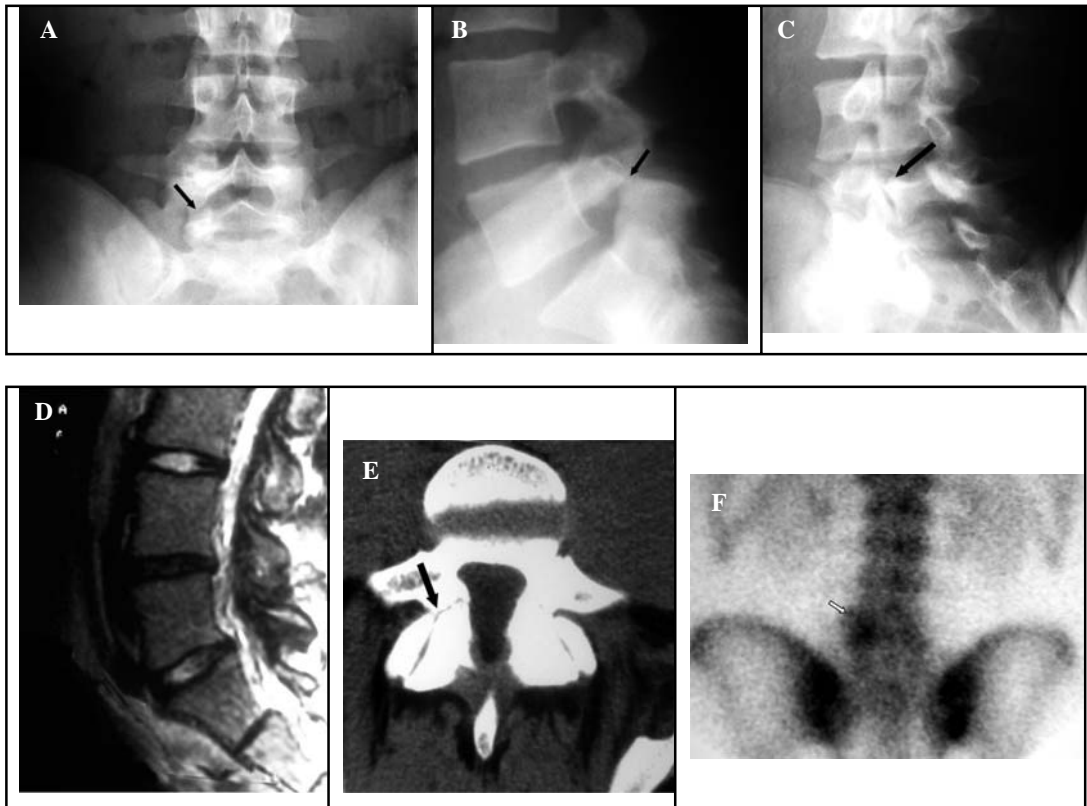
A–C, lateral and oblique radiographs of L5 pars fractures with minimal slip. A, Lateral view suggests an L5 pars defect. B and C, Obliques confirm the pars defects bilaterally at L5. D–F, MRI and technetium-99 bone scan imaging of L5 pars defect. D, Sagittal MRI shows desiccation of the L5–S1 disc. E, Arrow demonstrates the pars defect. F, Lateral SPECT technetium-99 bone scan reveals increased uptake at the L5 level. G and H, AP and lateral x-rays of pars repair surgical technique. L5 pedicle screw fixation bilaterally with a Songer cable wound around the spinous process and tightened securely compressing graft in the pars defects.
